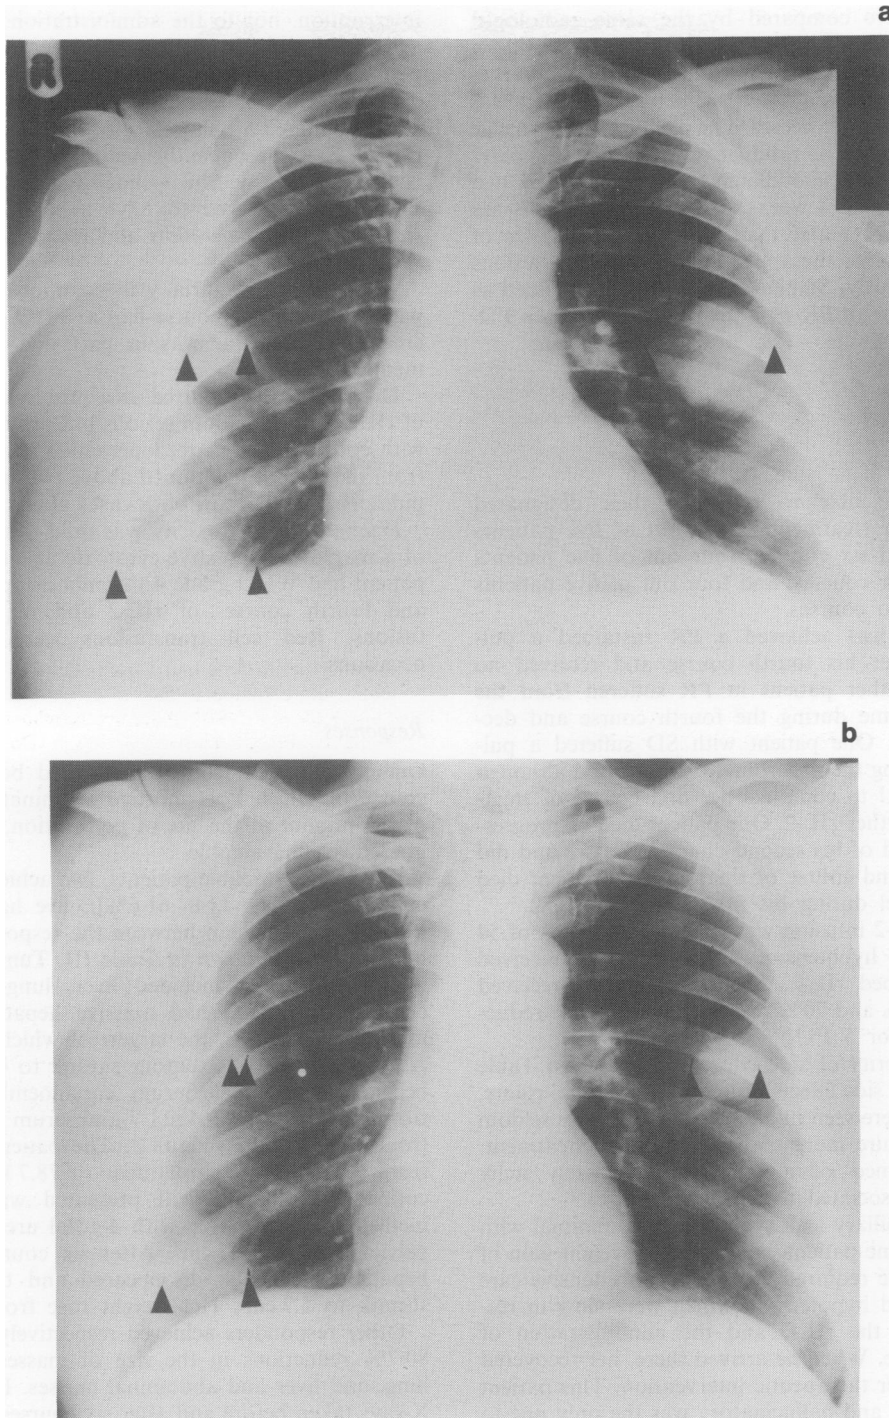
Chest radiographs before and after six courses of treatment in patient number 12.
